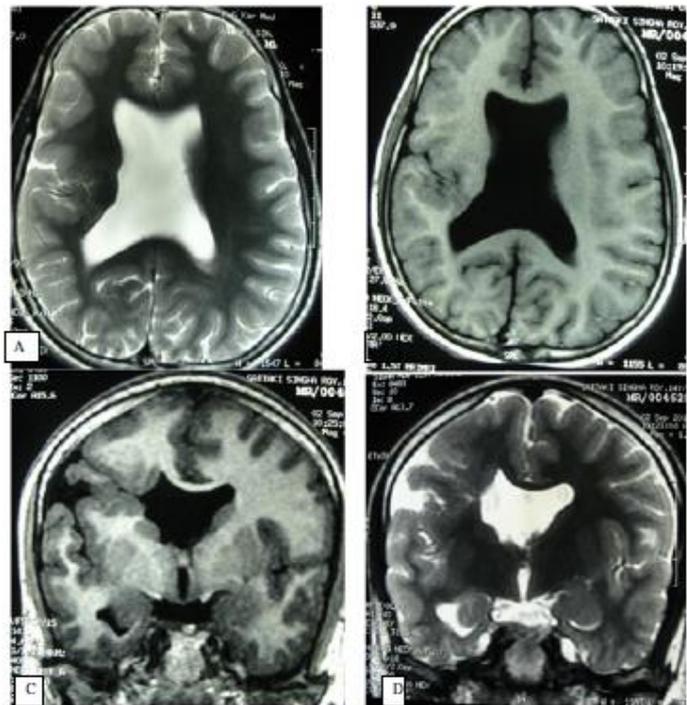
MRI different sequences a-axial T2 weighted, B- axial T1 weighted flair, C-coronal T1 weighted flair and D- coronal T2 weighted images, showing septo-optic dysplasia, type I schizencephaly of right side and heterotopia
